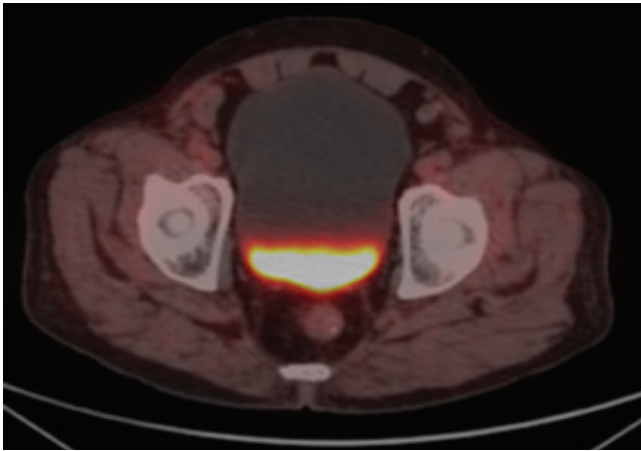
(b): PET-CT fused image in axial section showing Posterior layering of UB
